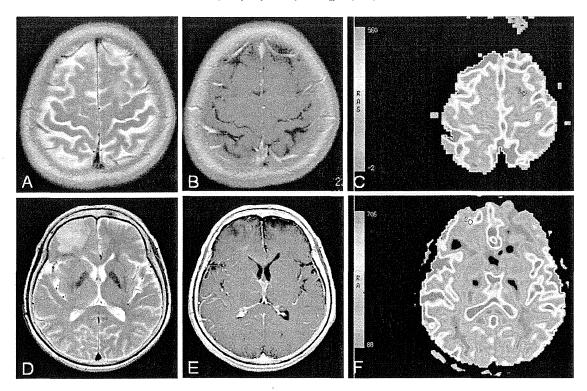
(A–C) A representative case of a diffuse astrocytoma. (A) Axial transverse T2-weighted image shows a left frontal tumor. (B) Axial contrast-enhanced transverse T1-weighted image shows the tumor without enhancement. (C) The rCBV map shows that the rCBVmax value of the tumor is 1.03. (D–F) Representative case of an anaplastic astrocytoma. (D) Axial transverse T2-weighted image shows a right frontal tumor. (E) Axial contrast-enhanced transverse T1-weighted image shows the tumor with partial enhancement. (F) The rCBV map shows that the rCBVmax value of the tumor is 2.85.
